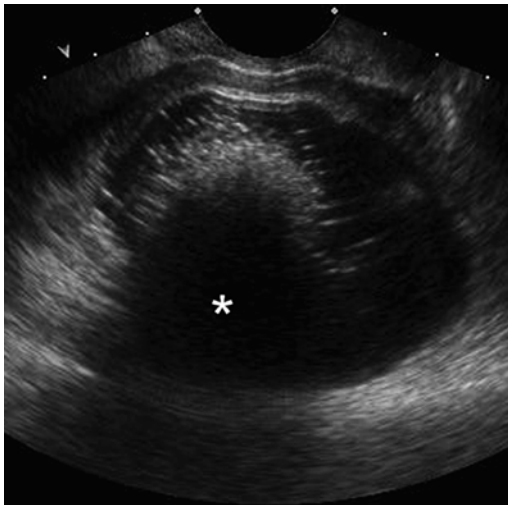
Ovarian teratoma on transvaginal ultrasound. The cystic adnexal mass has a central dense echogenic nodule (the Rokitansky nodule) causing posterior acoustic shadowing (\*). The Rokitansky nodule is composed of the fat, bone, and hair (Reprinted from Heilbrun et al. [3], with permission)
